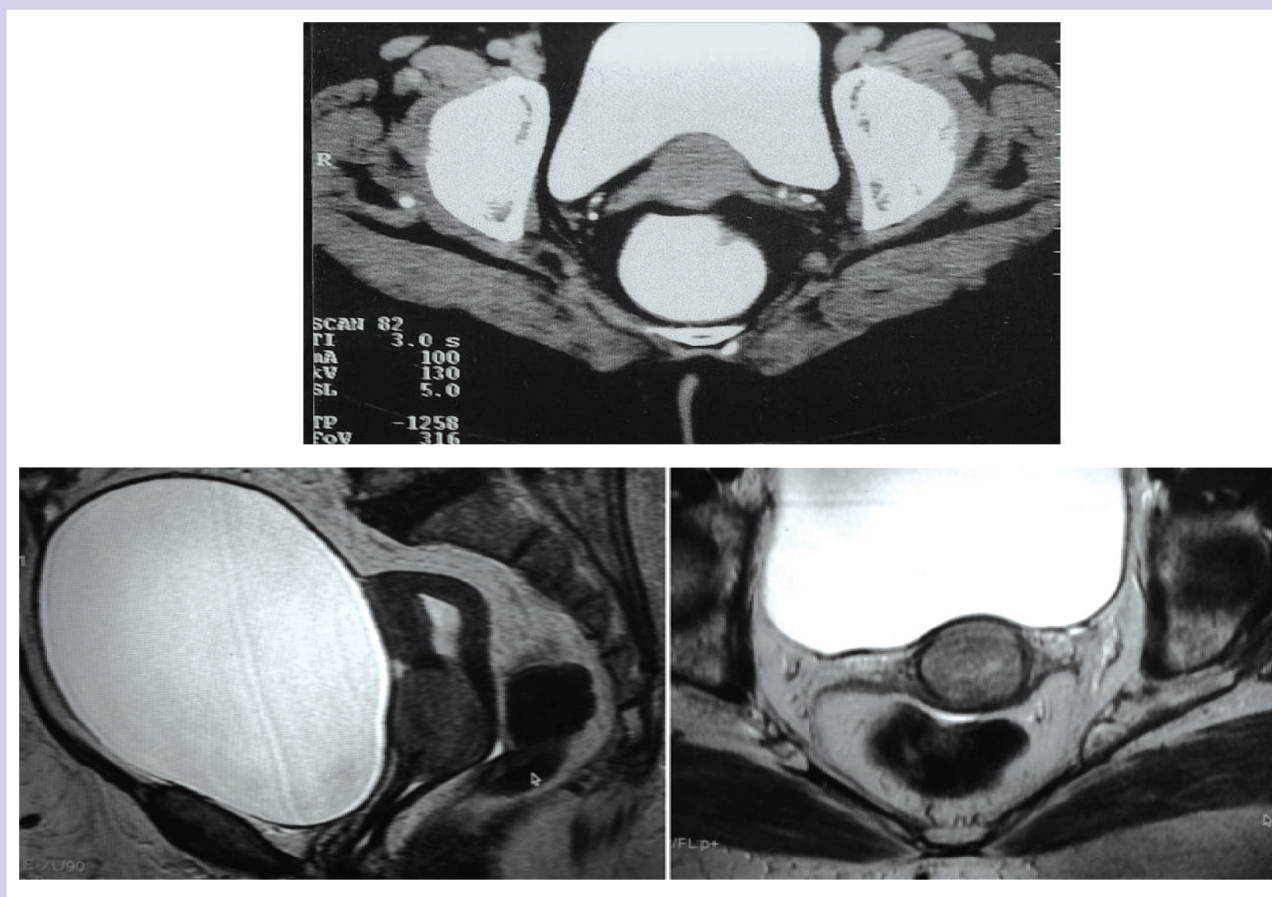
Carcinoma cervix - MRI and CT showing carcinoma localized to cervix (Stage IB)
